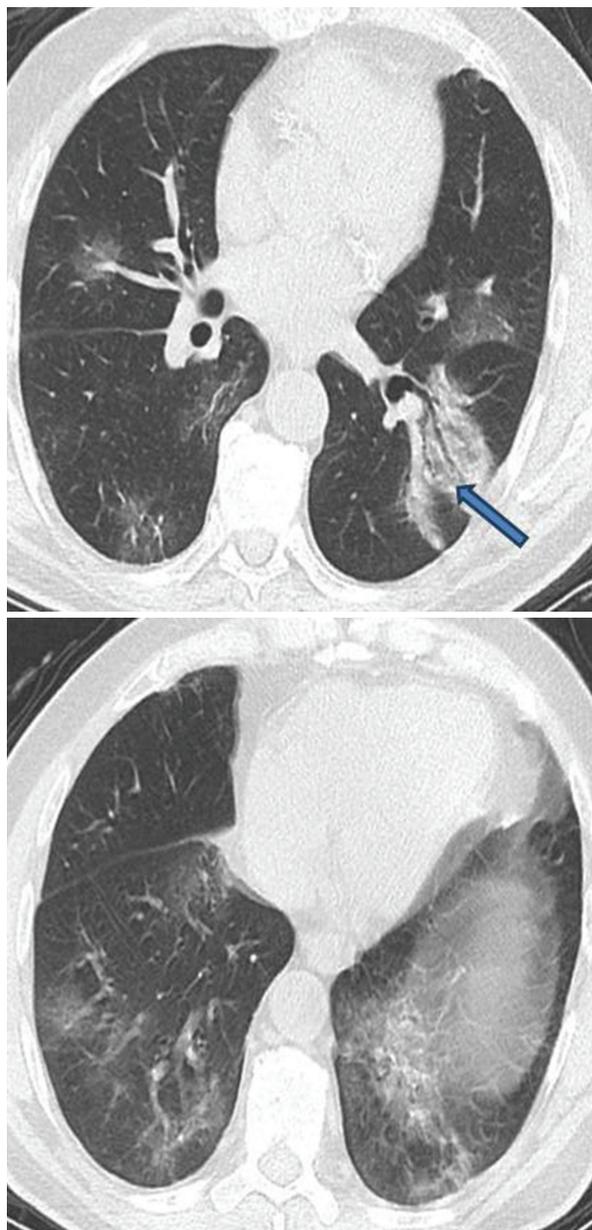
Female patient, 55 years old, was complaining of fever, dry cough and dyspnea and was confirmed to be COVID-19 by RT-PCR. These axial non-contrast CT chest images (lung window) show multifocal ground glass opacities involving both lower lobes as well as area of consolidation with air-bronchogram anterior segment of left lower lobe (blue arrow). Right lower lobe has score 4 (50% to < 75% involvement), left lower lobe has score 5 (with $\geq 75\%$ involvement) so total CT lung severity score is 9 with 36% of lung involvement
